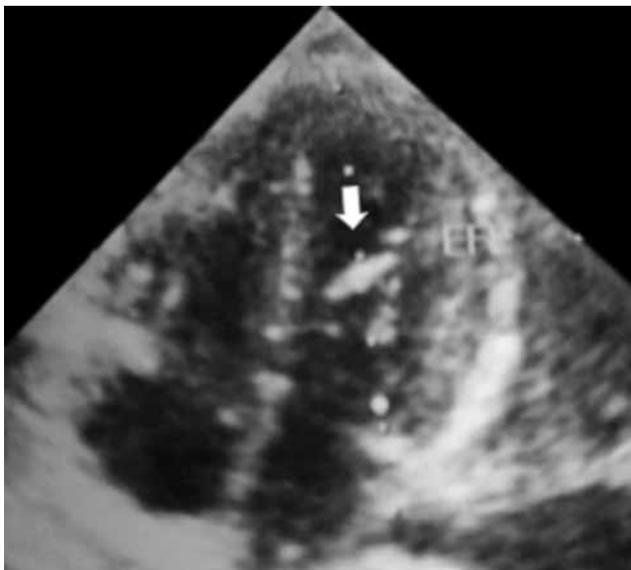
Parasternal four chamber echocardiographic view showing the endocardial fibroelastosis involving the papillary muscles of the mitral valve.
